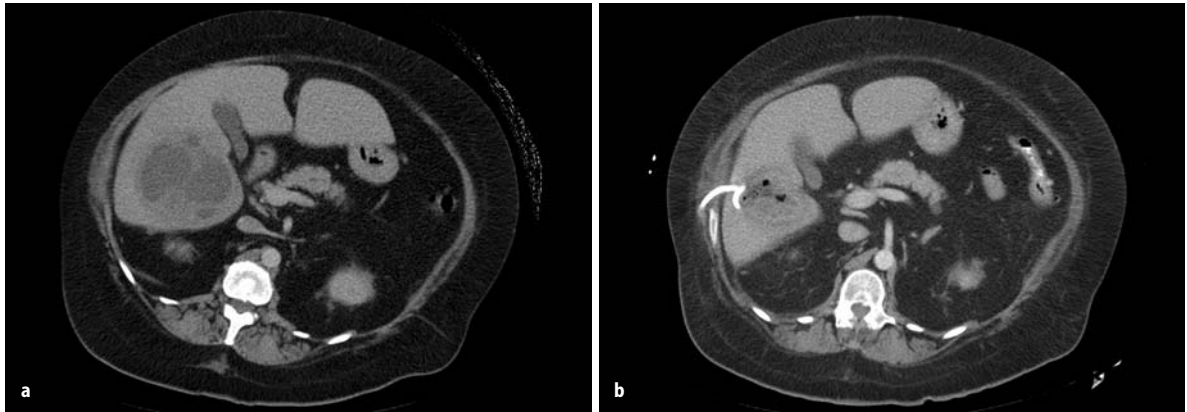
a CT findings of multiloculated pyogenic abscess of the right lobe of the liver. b Successful CT-guided drainage of multiloculated pyogenic abscess of the right lobe of the liver
